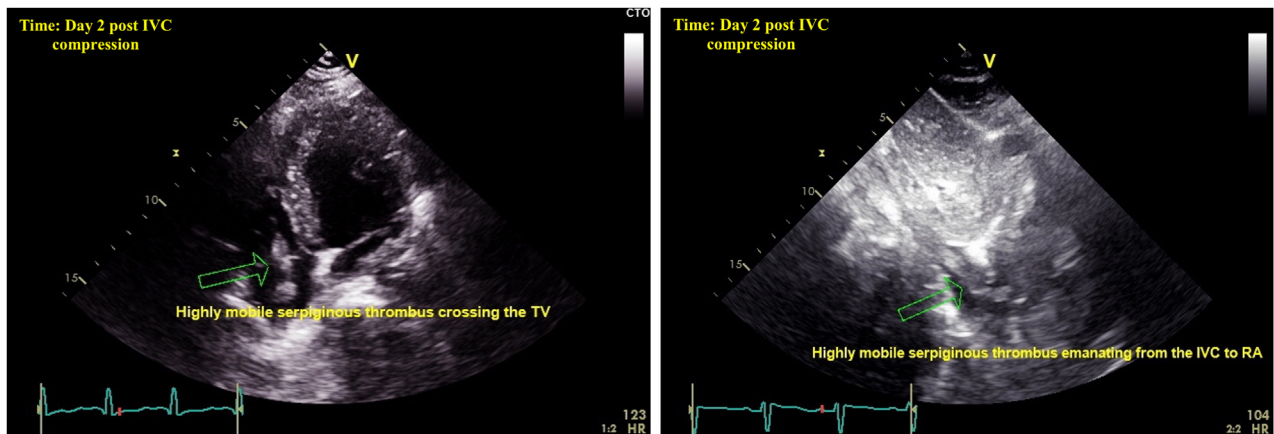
Two-dimensional TTE, apical 4-chamber view (*left*) and subcostal view (*right*) obtained 2 days later, demonstrates the thrombus (*arrow*) in the IVC, RA, and RV.
